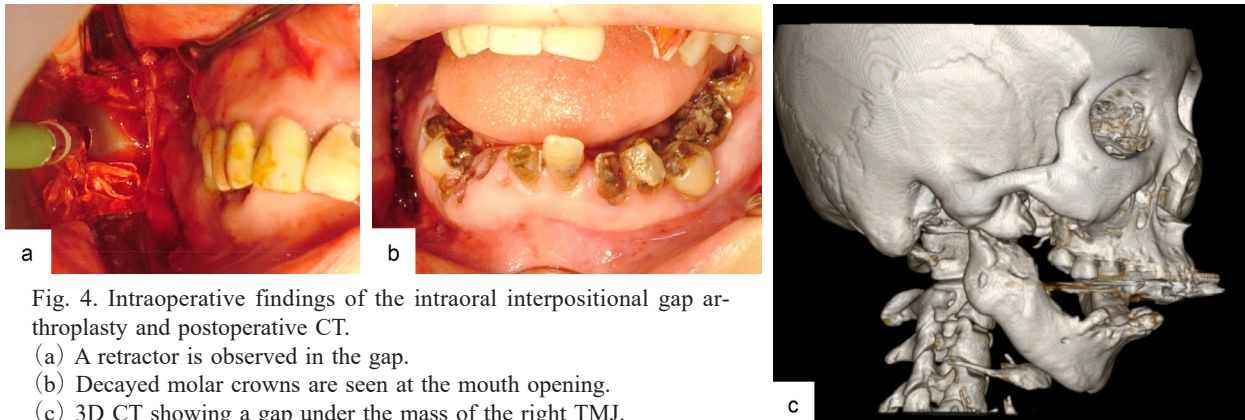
Intraoperative findings of the intraoral interpositional gap arthroplasty and postoperative CT.
